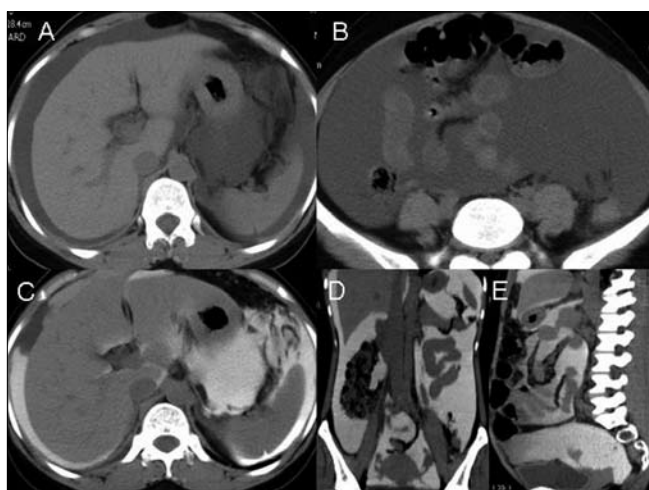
Axial, coronal, and sagittal reformatted CT images: A and B showing significant amount of intraperitoneal fluid; C, D, and E showing contrast into the intraperitoneal cavity.
